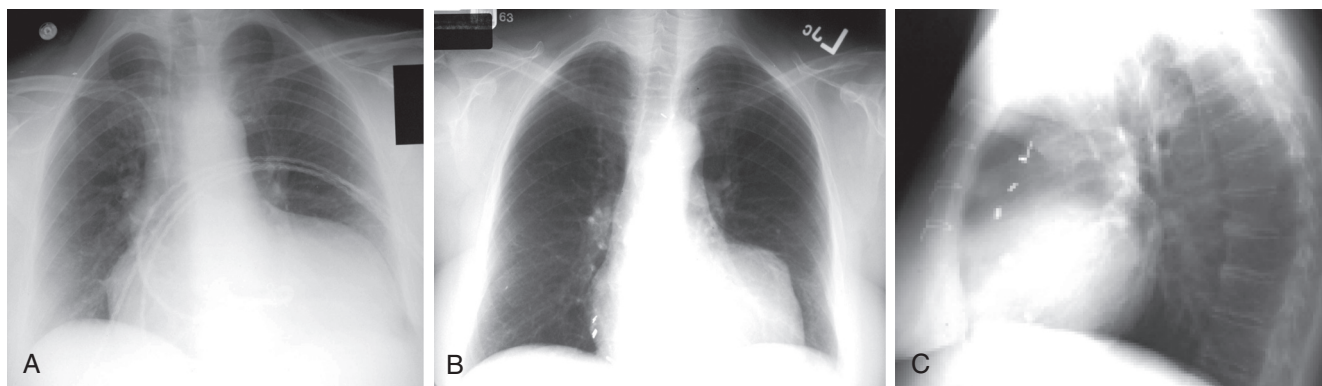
FIGURE e15-5 Chest radiographs of a 53-year-old woman with coronary artery disease and heart failure following a large anterolateral MI. A, Frontal portable view suggesting cardiomegaly and heart failure. The sharp horizontal contour of the left ventricle is suggestive of an anterior wall aneurysm. B, C, PA and lateral views after revascularization and aneurysmectomy demonstrating persistence of an abnormal contour of the left ventricle, consistent with recurrent aneurysm, and clips on side branches of the saphenous vein graft to the right coronary artery.
